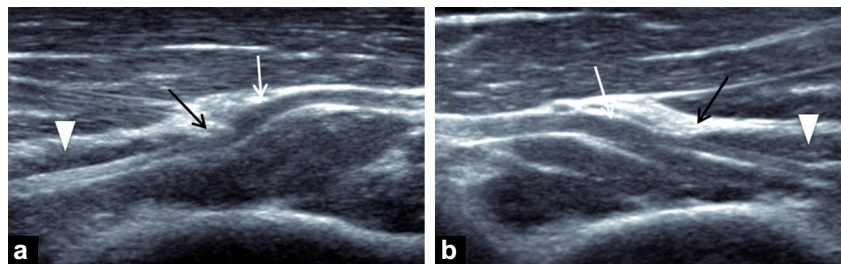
Local thickening of the deep branch of the radial nerve at the elbow, doubtful, in a context of lateral epicondylar pain resistant to medical treatment, not shown to be a radial tunnel syndrome on electromyogram. a: longitudinal ultrasound on the symptomatic right side: local thickening of the nerve (white arrows) as it passes beneath the Fröhse arcade (black arrows). Superficial head of the supinator muscle (arrowhead); b: the comparison with contralateral asymptomatic side shows a similar appearance.
